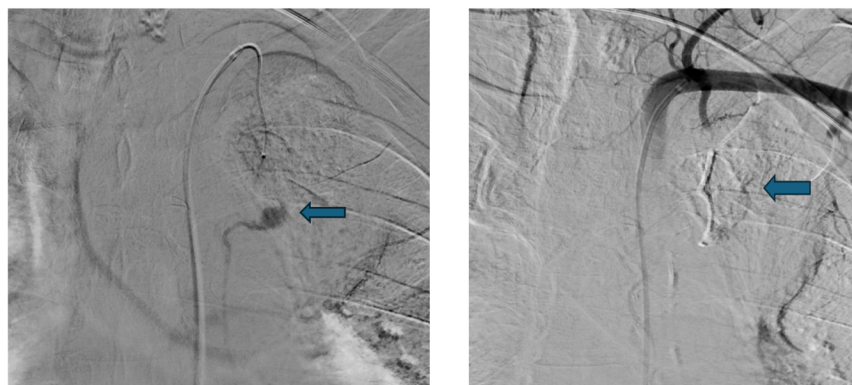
Focal out pouching representing pseudoaneurysm arising from left internal thoracic artery at the level of anterior second rib, measuring approximately 7 x 7 mm as noted on prior CT scan examination (left). Subsequently, using combination of 5 Fr guiding catheter, parkway microcatheter and .014 micro wire the left internal thoracic was cannulated and embolization was successfully performed using 0.5 mL Histoacryl glue and 1.5 mL of lipoidal solution (right).
